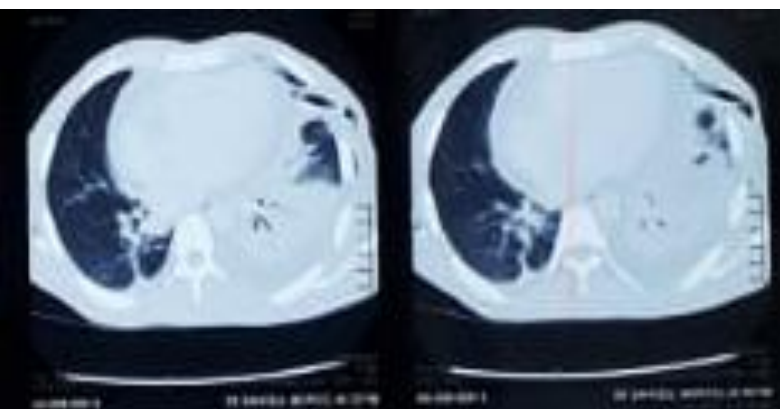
Contrast enhanced CT (CECT) scan of Thorax on Day 7 of admission showing liver abscess which has ruptured into the lung parenchyma and left pleural cavity
